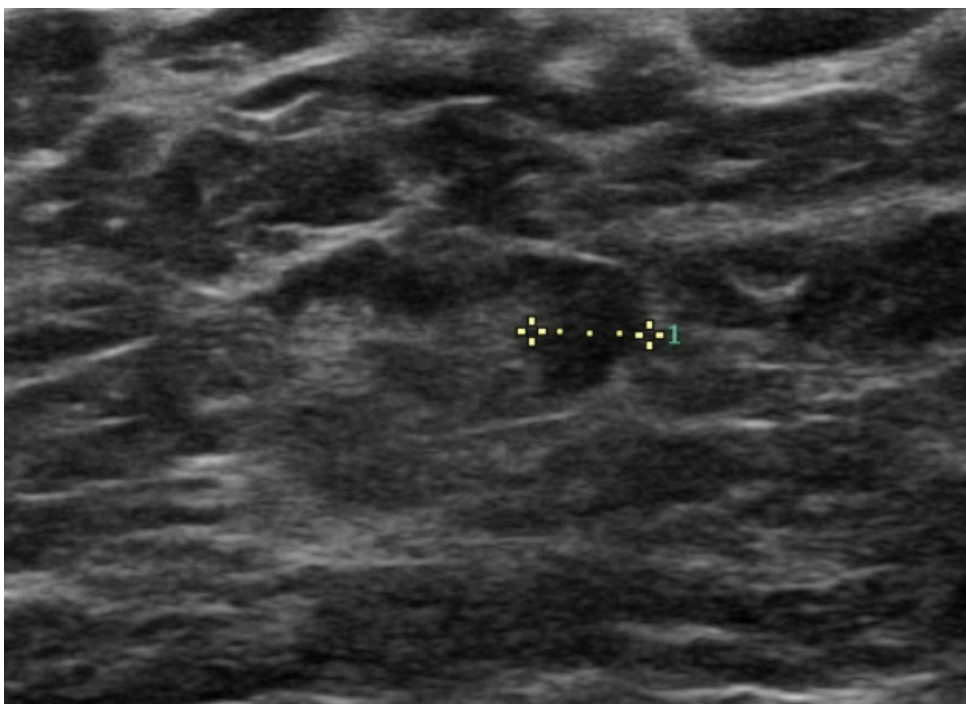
Ultrasound of an axillary lymph node with focal cortical thickening or cortical nodule, metastasis was confirmed.
